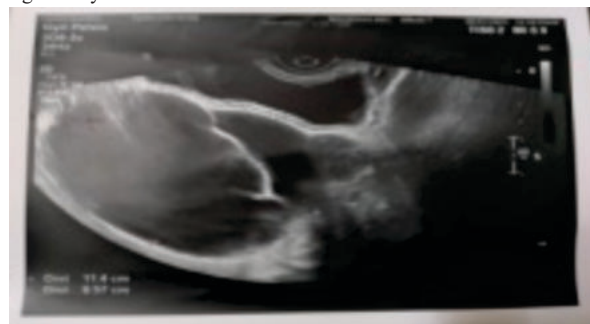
Ultrasonography Showing Anechoic Cystic Lesion Measuring 11 × 8.5 Cm with Few Internal Septations and Echoes in Right Ovary.
